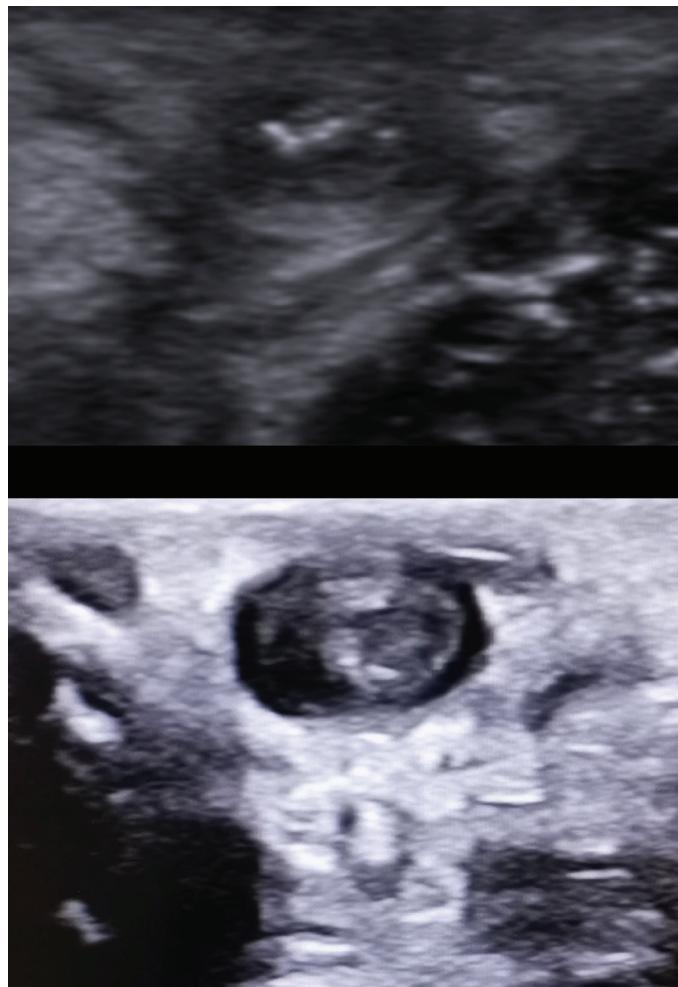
Bilaterally thrombotic occluded cephalic veins in ultrasonography.
